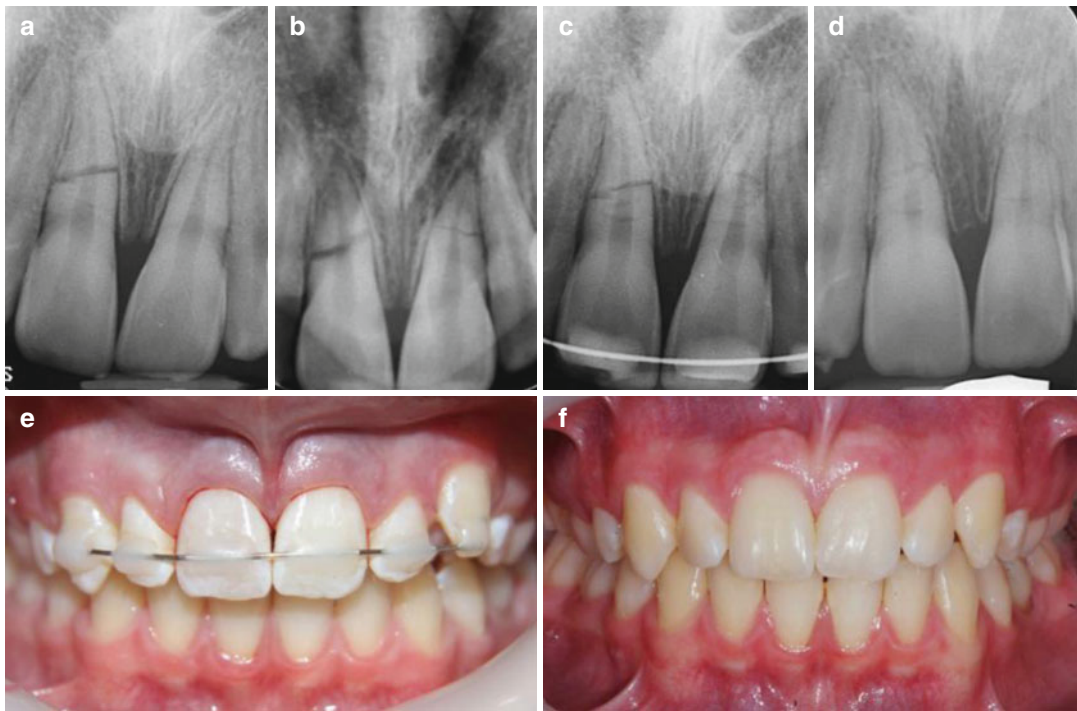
Clinical photographs and radiographs demonstrating middle 1/3 root fracture of tooth 11 and 21 and its management. Note (a) preoperative parallel view of the anterior maxillary teeth. Discernible fracture line evident in tooth 11. (b) Vertical tube shift revealing additional fracture line in tooth 11. (c) Repositioning of fractured segments with a semirigid splint. (d) The splint was removed following a period of 2 months. The patient was reviewed a further 6 months later. Note pulp canal
